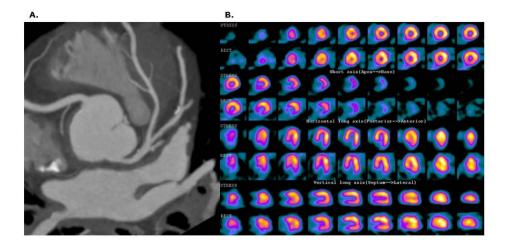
Coronary CT angiography and SPECT images in a 62-year-old man with chest pain who experienced ischemic stroke 1 year after coronary evaluation. (A) Thin-slap maximum intensity projection image of coronary CT angiography shows atherosclerotic plaques in the left main, left circumflex artery and diagonal branch. (B) Myocardial SPECT images demonstrate no perfusion defect.
